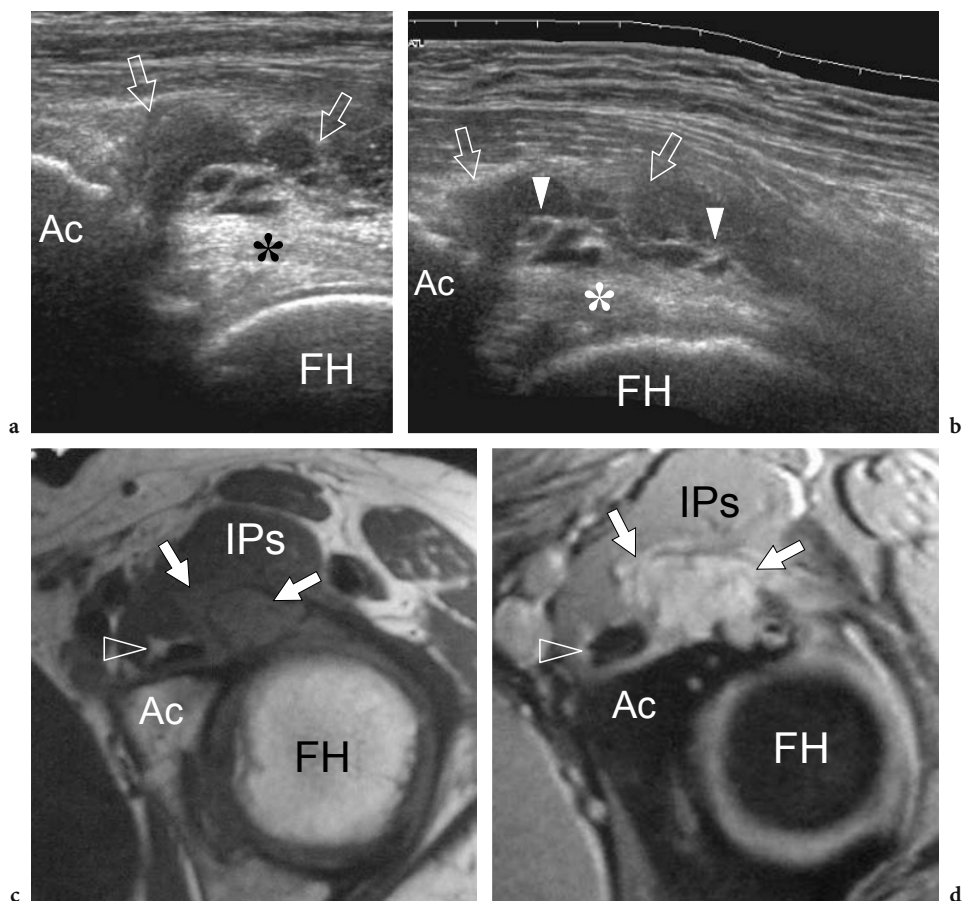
Anterior ganglion cyst. a Transverse and b sagittal extended field-of-view 12–5 MHz US images obtained over the anterior aspect of the hip demonstrate a ganglion cyst (*arrows*) which appears as a complex mass with fluid-filled cavities and prominent echogenic septations (*arrowheads*). Note the close relationship between the cyst and the anterosuperior labrum (*asterisk*). *Ac*, acetabulum; *FH*, femoral head. c Transverse T1-weighted and d fat-suppressed T2-weighted MR images. In c, the ganglion (*arrows*) appears isointense relative to the iliopsoas muscle (*IPs*) and tendon (*arrowhead*), whereas in d it exhibits hyperintense signal. Internal septations are barely visible
